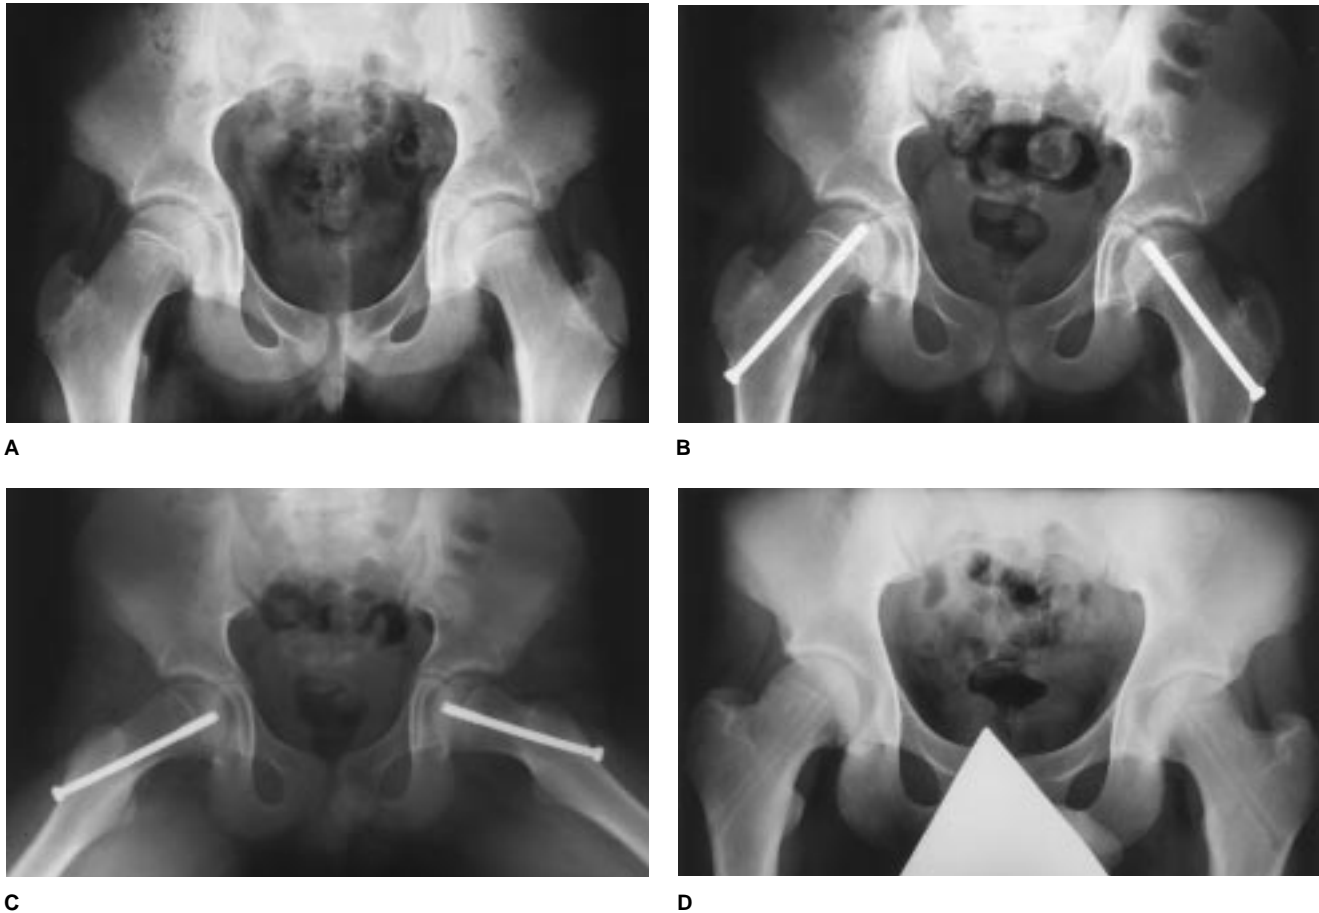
Images of the pelvis of a 17-year-old boy (bone age, 13 years) with tetralogy of Fallot and bilateral groin pain. A, Anteroposterior radiograph shows bilateral mild SCFE. B, Postoperative radiograph shows satisfactory central position of the screws. C, Postoperative frog-leg lateral radiograph demonstrates satisfactory screw position (i.e., directed anterior to posterior and engaging the center of the epiphysis perpendicular to the physis). D, Screws were removed percutaneously 3 years 4 months after the initial operation. Postoperative radiograph shows a satisfactory result.
